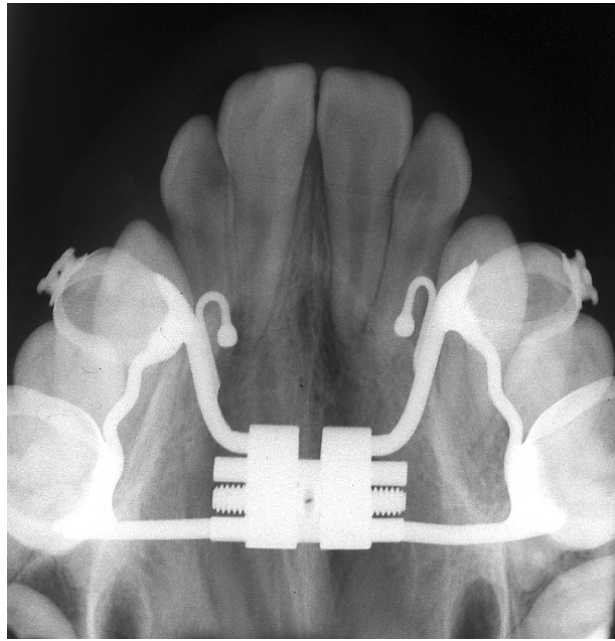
Maxillary occlusal radiograph before active RME showing normal midpalatal
